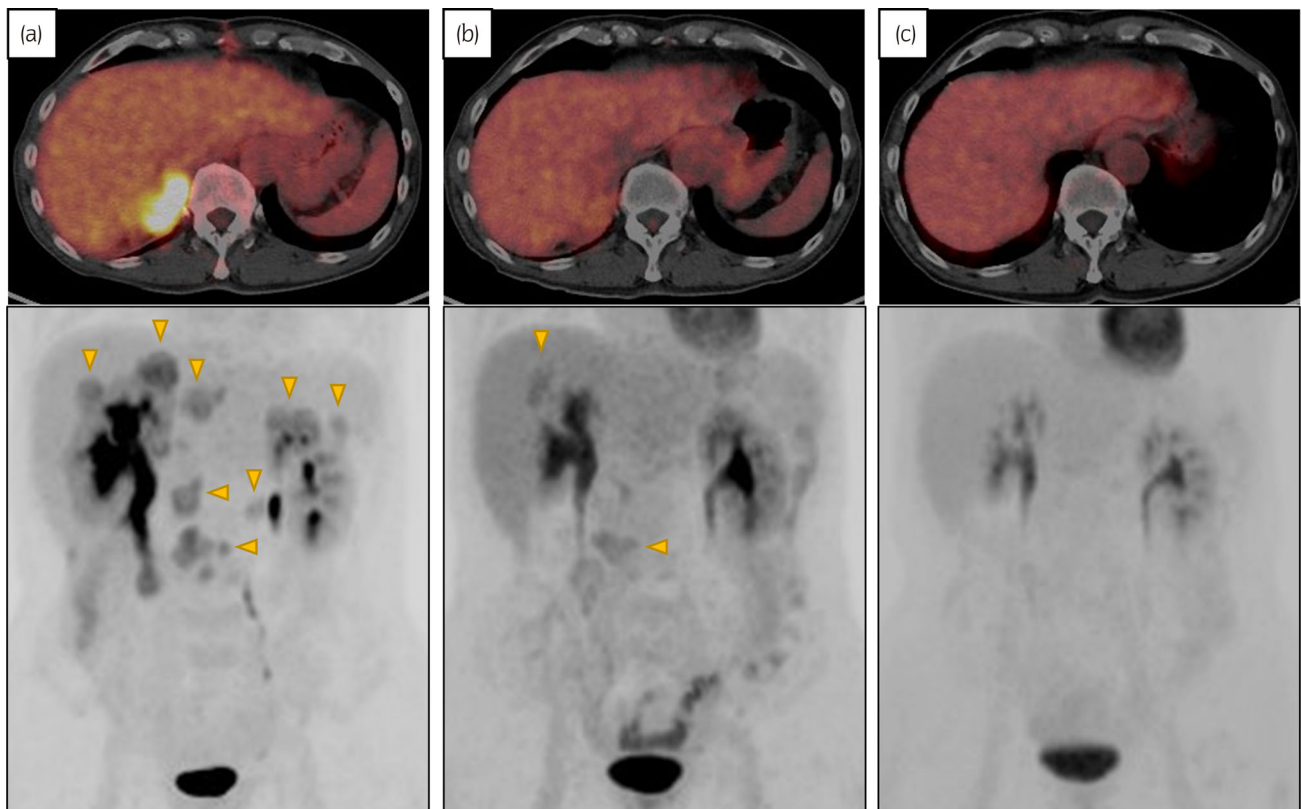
FDG-PET findings before (a) and after one (b) and four (c) courses of pembrolizumab. In addition to local recurrence on the dorsal side of the liver, numerous peritoneal dissemination lesions were observed before treatment; however, all the lesions regressed after one course, and all disappeared after four courses. Yellow arrowheads indicate peritoneal dissemination lesions.
